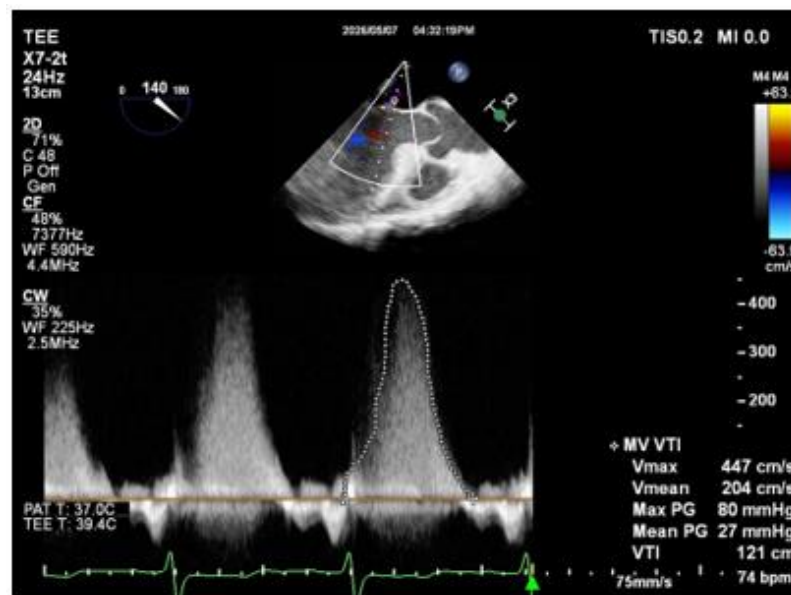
Post-revascularization intraoperative transesophageal echocardiography (TEE) in Case 2. Continuous-wave Doppler assessment demonstrating regression of mitral regurgitation severity following coronary artery bypass grafting
